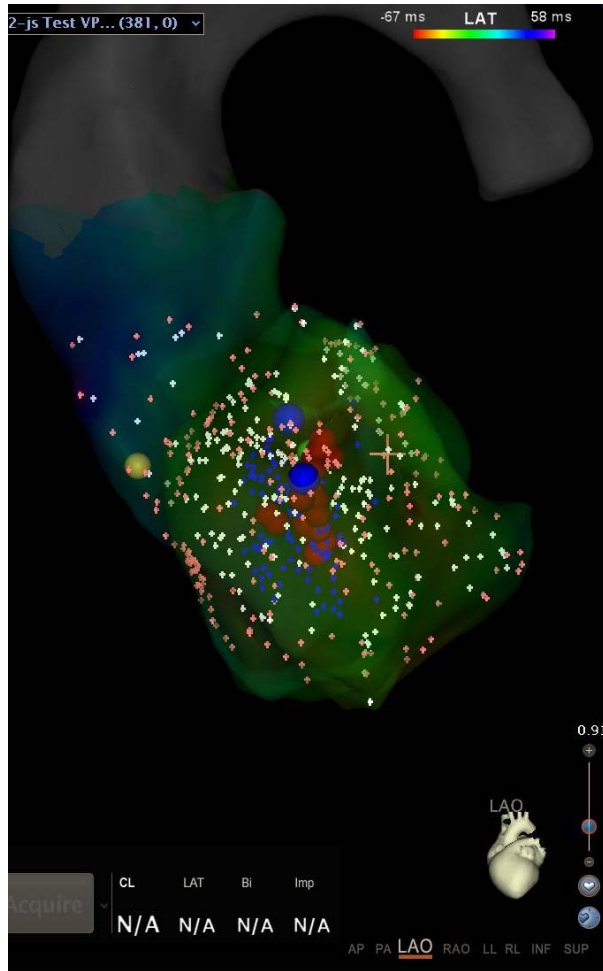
(A) Intracardiac ultrasound is performed to assist ablation of arrhythmias rising from left anterolateral papillary muscle. (B, C) It allows clear visualization and confirmation of contact with the anterolateral and posteromedial muscles. ([A] From Liu XK, Barrett R, Packer DL, et al. Successful management of recurrent ventricular tachycardia by electrical isolation of anterolateral papillary muscle. Heart Rhythm 2008;5(3):481; with permission.)
